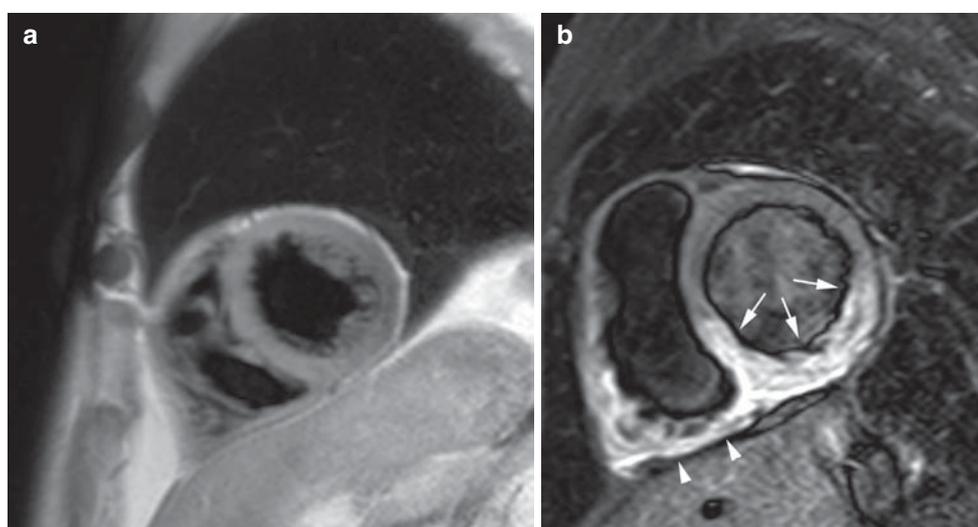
Assessment of cardiac morphology with fast spin-echo. Cardiac morphology can be assessed with fast spin-echo sequences and “black-blood” pre-pulses. A single-phase image in mid-diastole is usually acquired, to minimize motion artefact. These images can be T1- or T2-weighted, with or without fat suppression. (a) T1-weighted short-axis image (without fat suppression) of a normal heart. (b)
